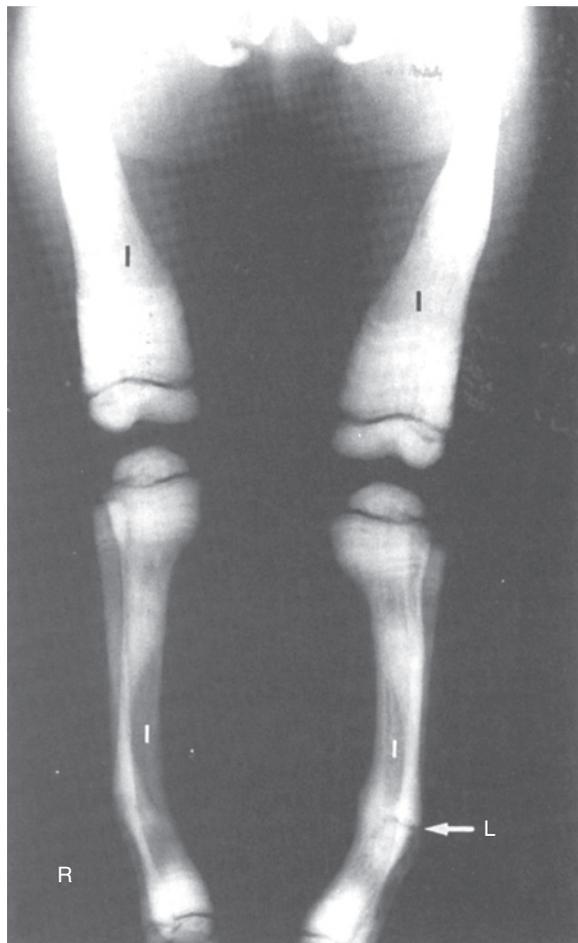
A radiograph of the long bones of a 6-year-old with an intermediate form of osteopetrosis shows the presence of some intramedullary space (denoted as “I”). The deformities of modeling result in bowing and thickening of the shaft and metaphyseal regions of the bone. Note a fracture, which was clinically not apparent, is present in the left tibia (arrow).
